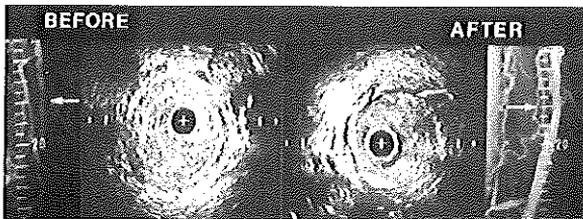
Angiographic and intravascular ultrasonographic cross sections obtained from superficial femoral artery before and after balloon angioplasty. Before intervention, concordant classification is obtained from angiography and ultrasonography. At level 18 stenosis of greater than 90% was observed. Lesion is classified as concentric soft. After intervention, dissection is seen both angiographically and on ultrasonography. Angiography judges stenosis as less than 50%; ultrasonography, however, reveals 50% to 90% stenosis. Lesion is seen dissected from arterial wall. *Plus sign* indicates catheter; calibration, 1 mm.
